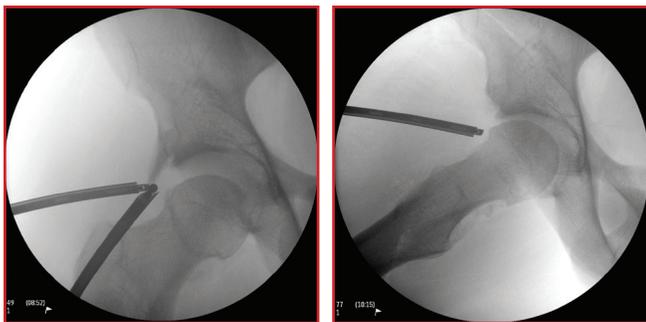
Intraoperative x-rays of right hip
